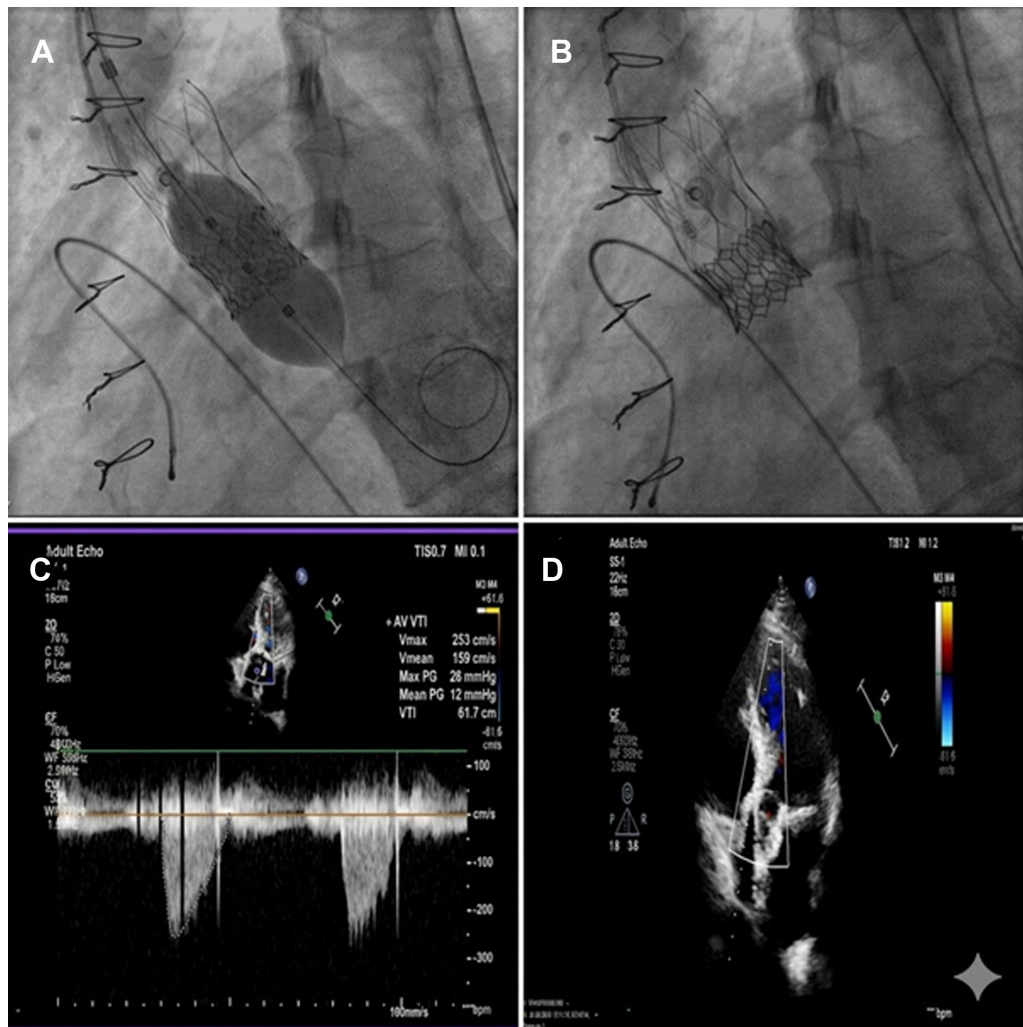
Intra-procedural ViViV execution and post-procedural outcomes. (A, B) Fluoroscopy showing precise positioning and deployment of the 24.5 mm Myval balloon-expandable valve within the 26 mm Portico frame. (C, D) Post-procedural TTE CW Doppler demonstrating gradient reduction to 26/12 mmHg and minimal residual regurgitation. CW, continuous-wave; TTE, transthoracic echocardiography; ViViV, valve-in-valve-in-valve.
